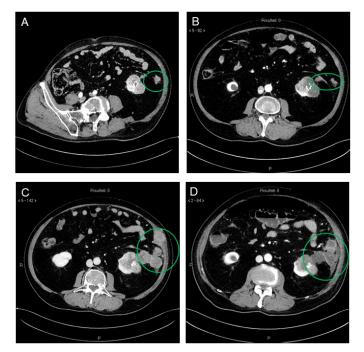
serial abdomen contrast-enhanced CT-scan, centred on the biopsy needle track. (A) initial diagnosis (may 2023); (B) 3-month follow-up (august 2023); (C) 4-month follow-up (september 2023), (D) 5-month follow-up (october 2023). green circle: progression of the nodular tumor masses in the perirenal tissue and along the biopsy track to the skin.
